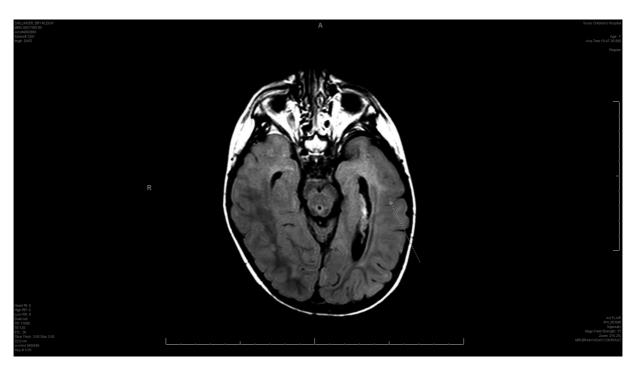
3Tesla axial magnetic resonance imaging brain showing bilateral tubers with small, malrotated left hippocampus.
